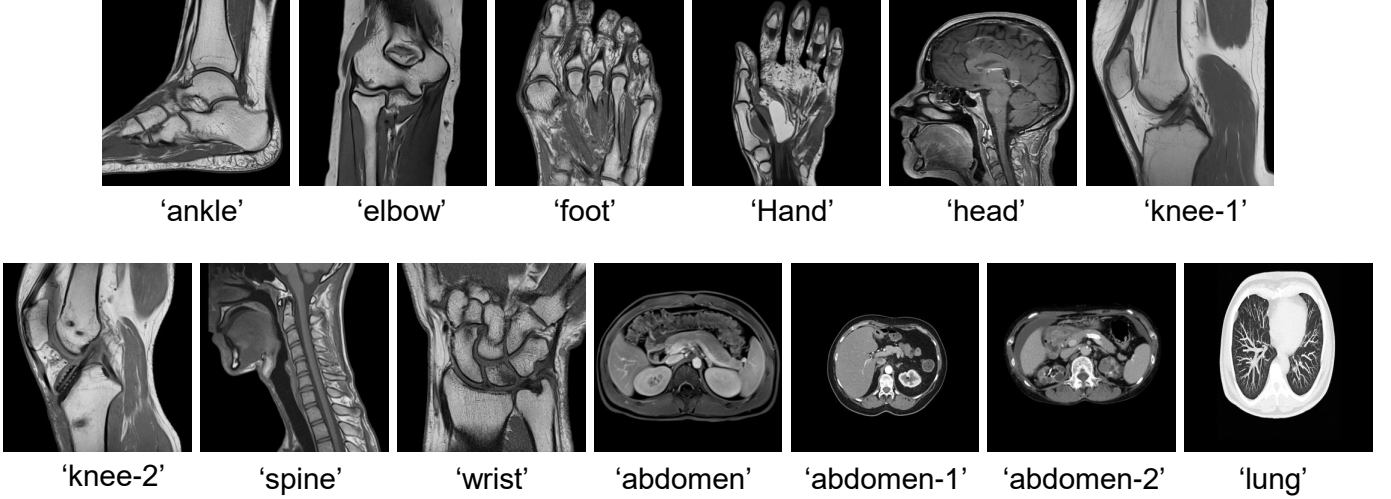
The MR images in the dataset MRI13.
